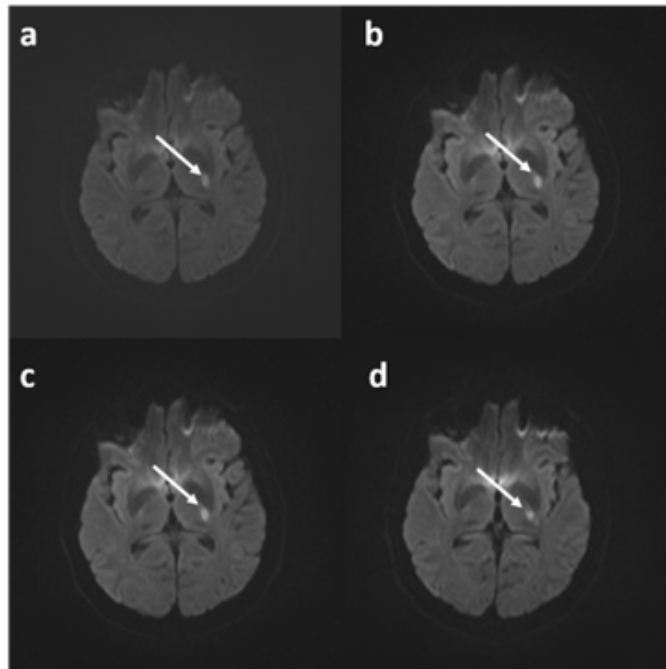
MRI layer Section 3: Acute stroke in the brain has been identified in a 44-year-old lady. Various b-values have been employed to improve the diagnosis of acute stroke: 0-1000 mm/s² (a) and 100-1000 mm/s² (b). 200-1000 mm/s² (c) and 300-1000 mm/s² (d). The findings indicate that b-values between 0 and 3000 mm/s² are superior than other values.
